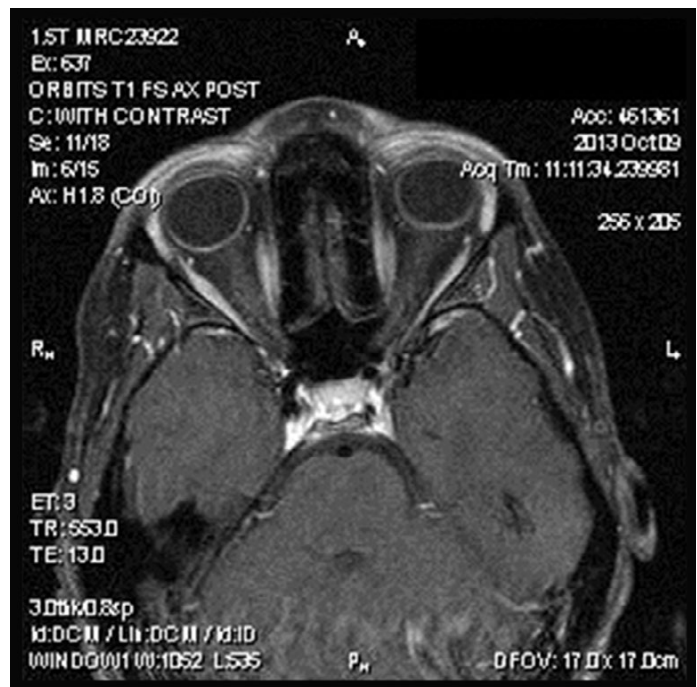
MRI axial cross section reveals no masses or abnormalities. Flattening of the posterior globe in the left eye.
